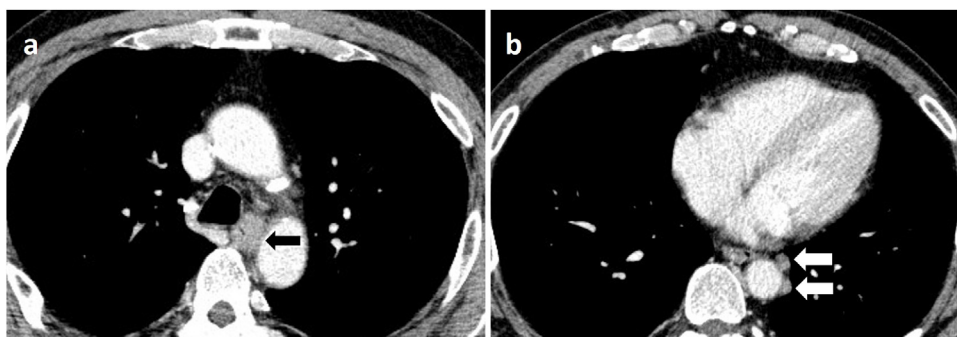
Computed tomography images. Computed tomography images show a thick wall in the upper thoracic esophagus (a) and lymph node swelling in the dorsal area of the thoracic aorta (b).
